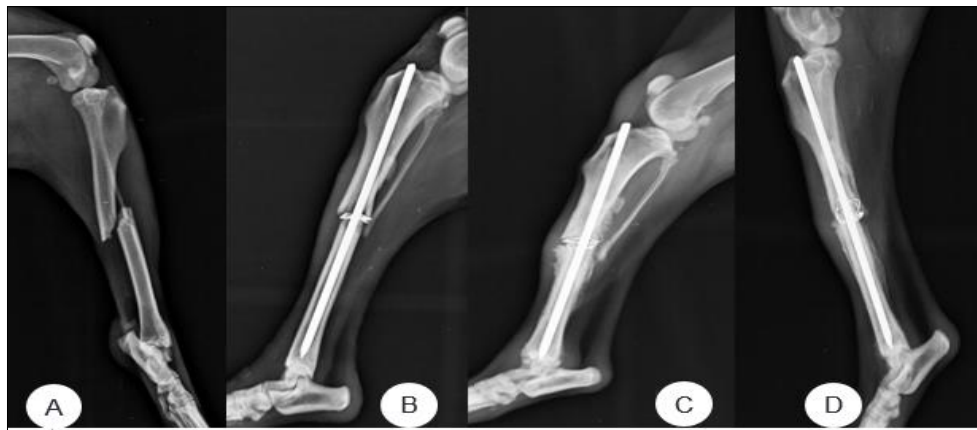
Mediolateral radiographic views of tibia with short oblique diaphyseal fracture (A) treated with open method just after surgery (B) and at 15 (C) and 30 (D) days post surgery.
